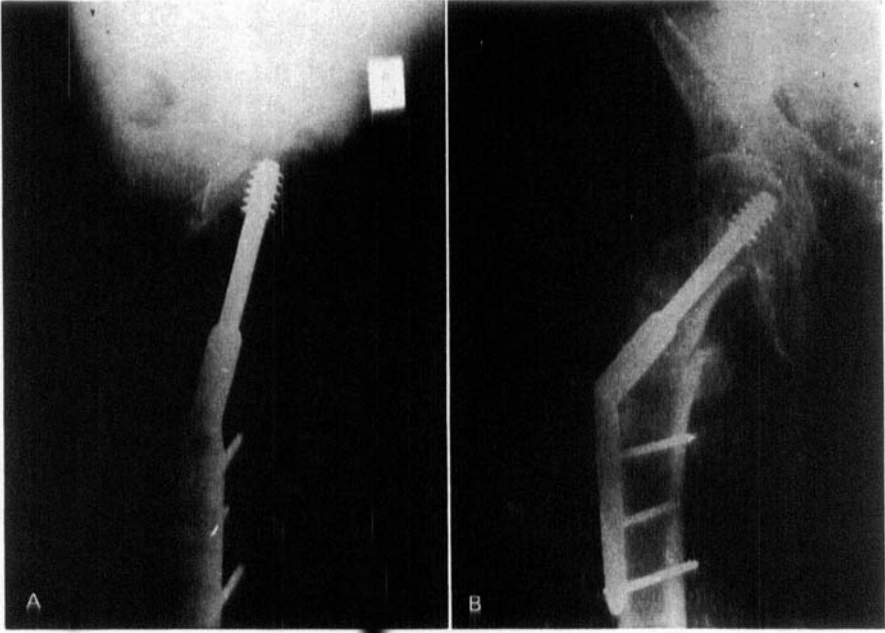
Routine radiographs after completion of Richards osteosynthesis on a intertrochanteric fracture.
